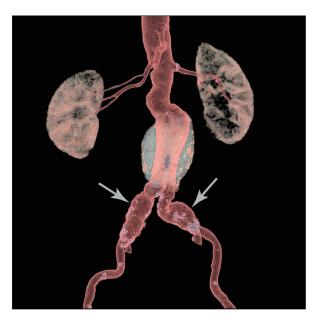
CTA reconstruction in a patient with AAA combined with bilateral CIAA (arrows)
